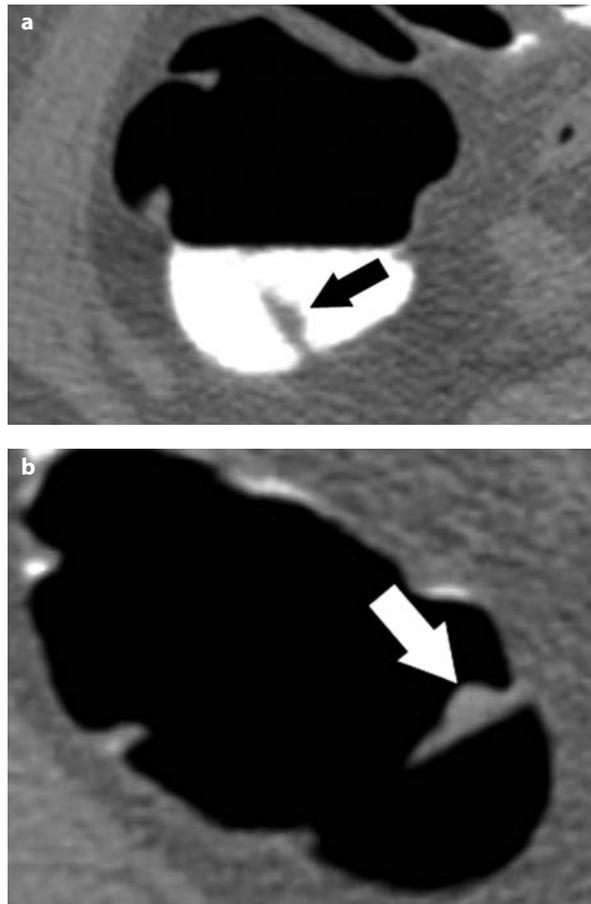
a, b. Patient with a 15-mm polyp at CT-colonography after extensive bowel preparation and fluid tagging. a Two-dimensional image with the patient in the supine position demonstrates the polyp (*arrow*) submerged by tagged fluid. Without tagging, the polyp would not have been identified in this patient position. b Two-dimensional image obtained with the patient in the prone position nicely shows the polyp (*arrow*), in this position without surrounding fluid
